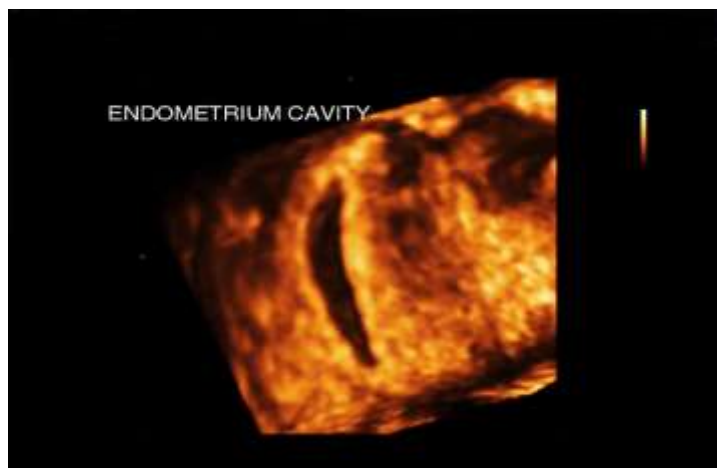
3D hysterosonography with volume rendering of normal endometrial cavity
